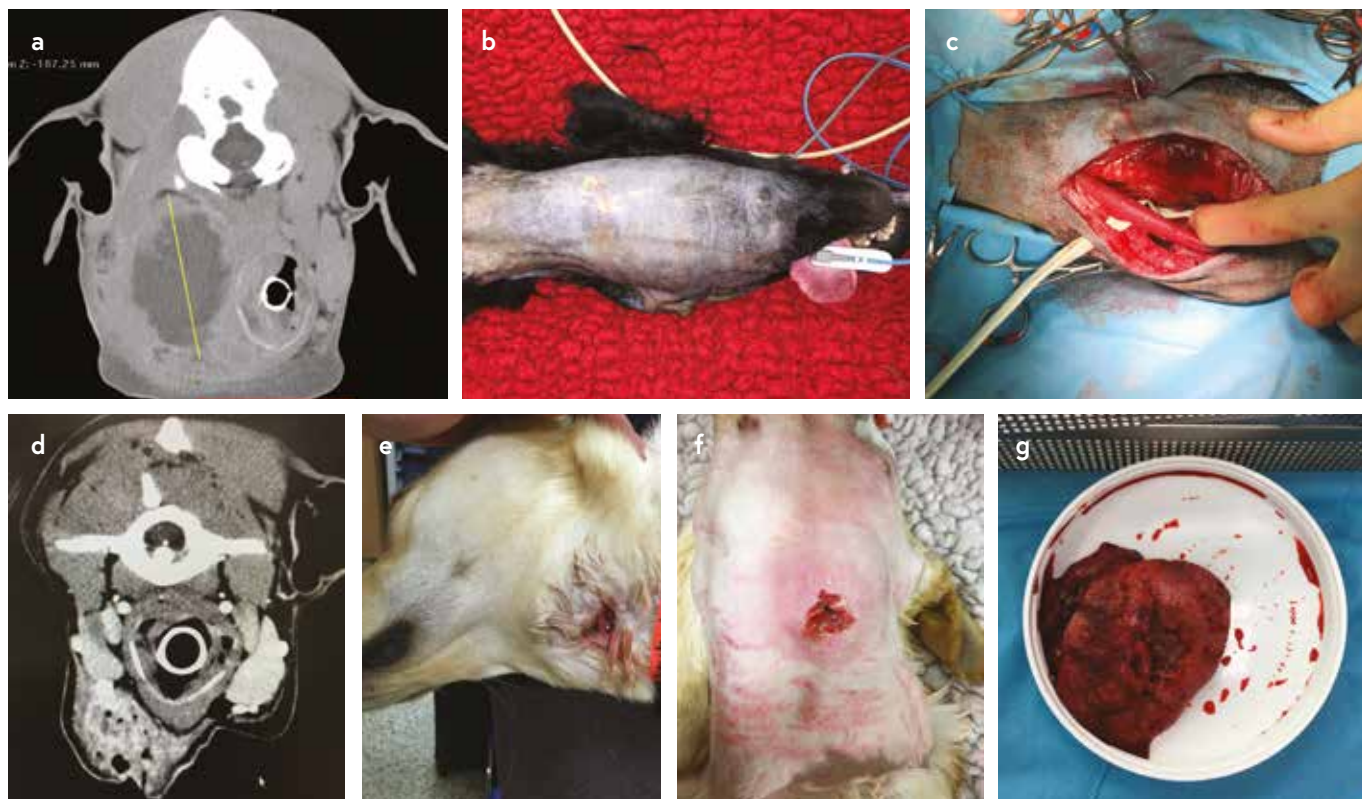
Chronic stick injuries. (a–c) First case, with a large, nonmobile, painful swelling on the ventral cervical neck. Computed tomography scan showing a large, chronic, fluid-filled cavity close to the larynx. Ventral approach to the neck, surgical exploration, debridement, and passive drain placement. (d–g) Second case, with a subcutaneous fistula. Computed tomography scan, physical and surgical exploration, and excised tissue after debridement.
